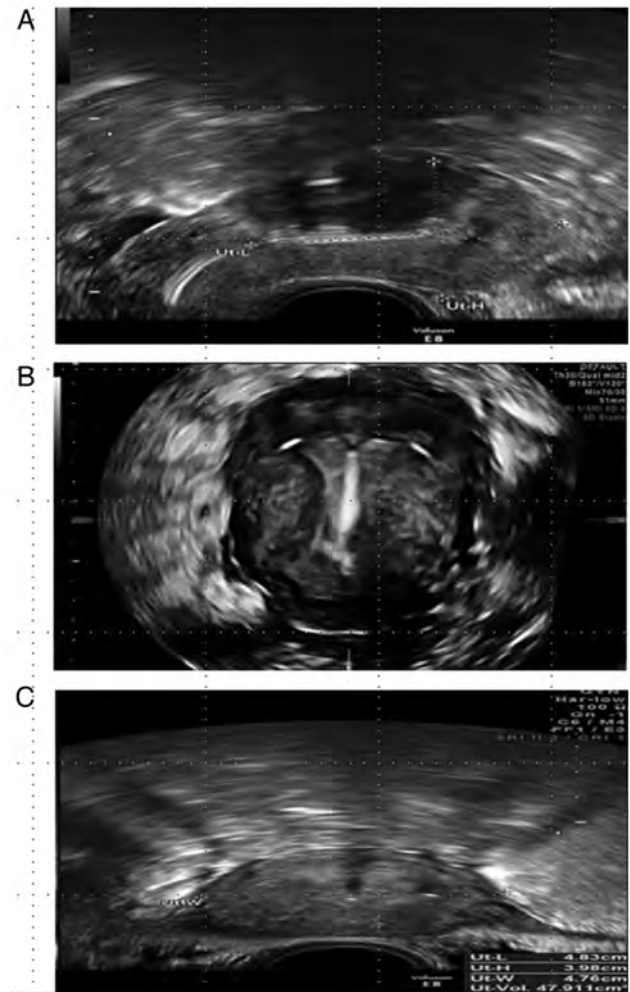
Intracavitary IUD. (A and B) 2D ultrasound longitudinal plane and transverse plane showing a normal position of the IUD in the cavity. (C) 3D ultrasound with coronal plane showing the IUD embedded in the myometrium. 2D, two dimensional; 3D, three dimensional; IUD, intra-uterine device.
